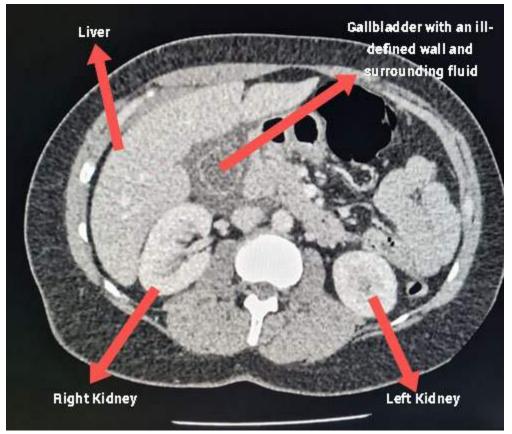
Axial View of the CT abdomen at the level of the gallbladder, showing signs of gallbladder rupture.
